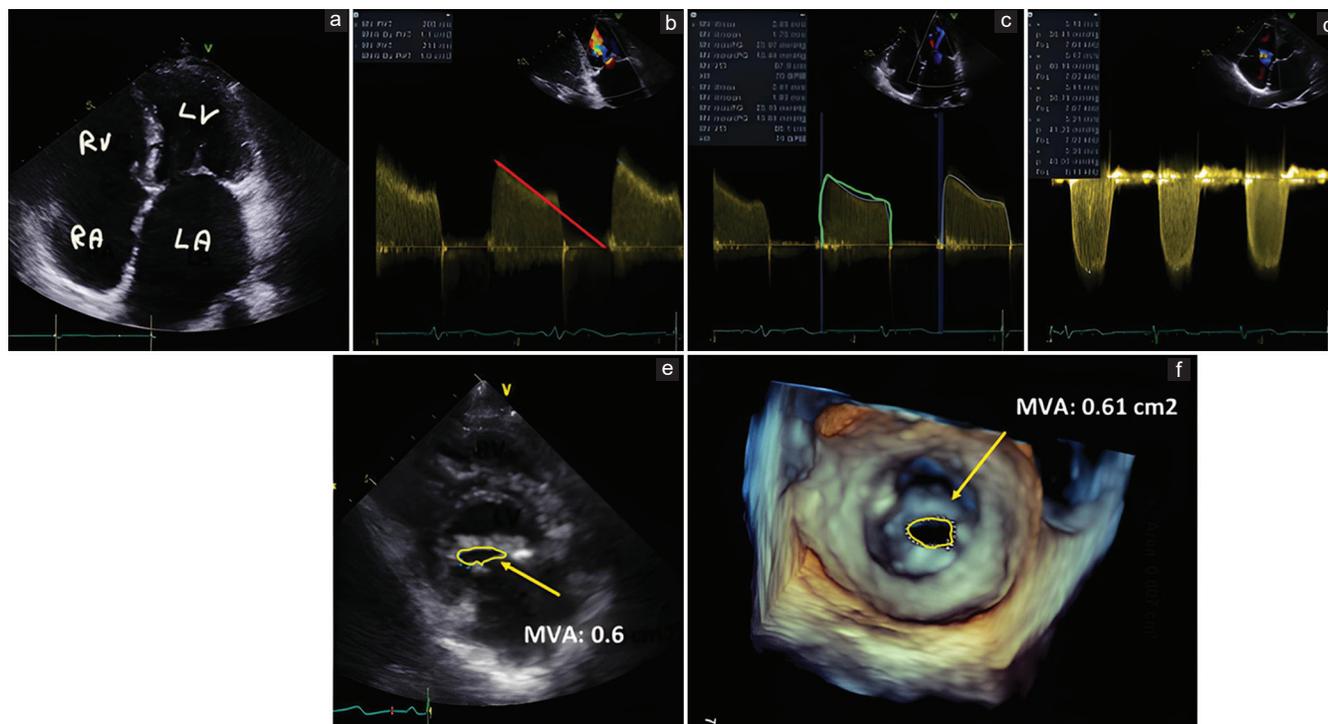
(a) 4 chamber view: severely dilated atria. (b) MV area was evaluated using PHT method (220/PHT) or by 2D planimetry (e) and 3D planimetry (f). (c), (d) Peak and mean mitral gradients were obtained from the apical position using CW Doppler recordings for the estimation of MV stenosis severity (peak and mean gradients)
